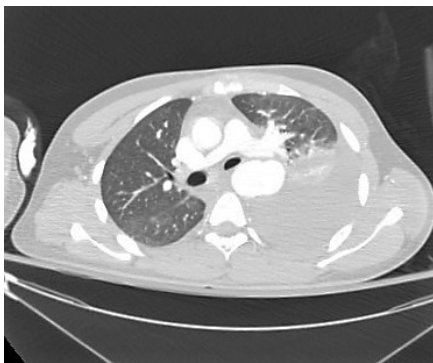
Pre-op CT showing Massive Left Haemothorax
